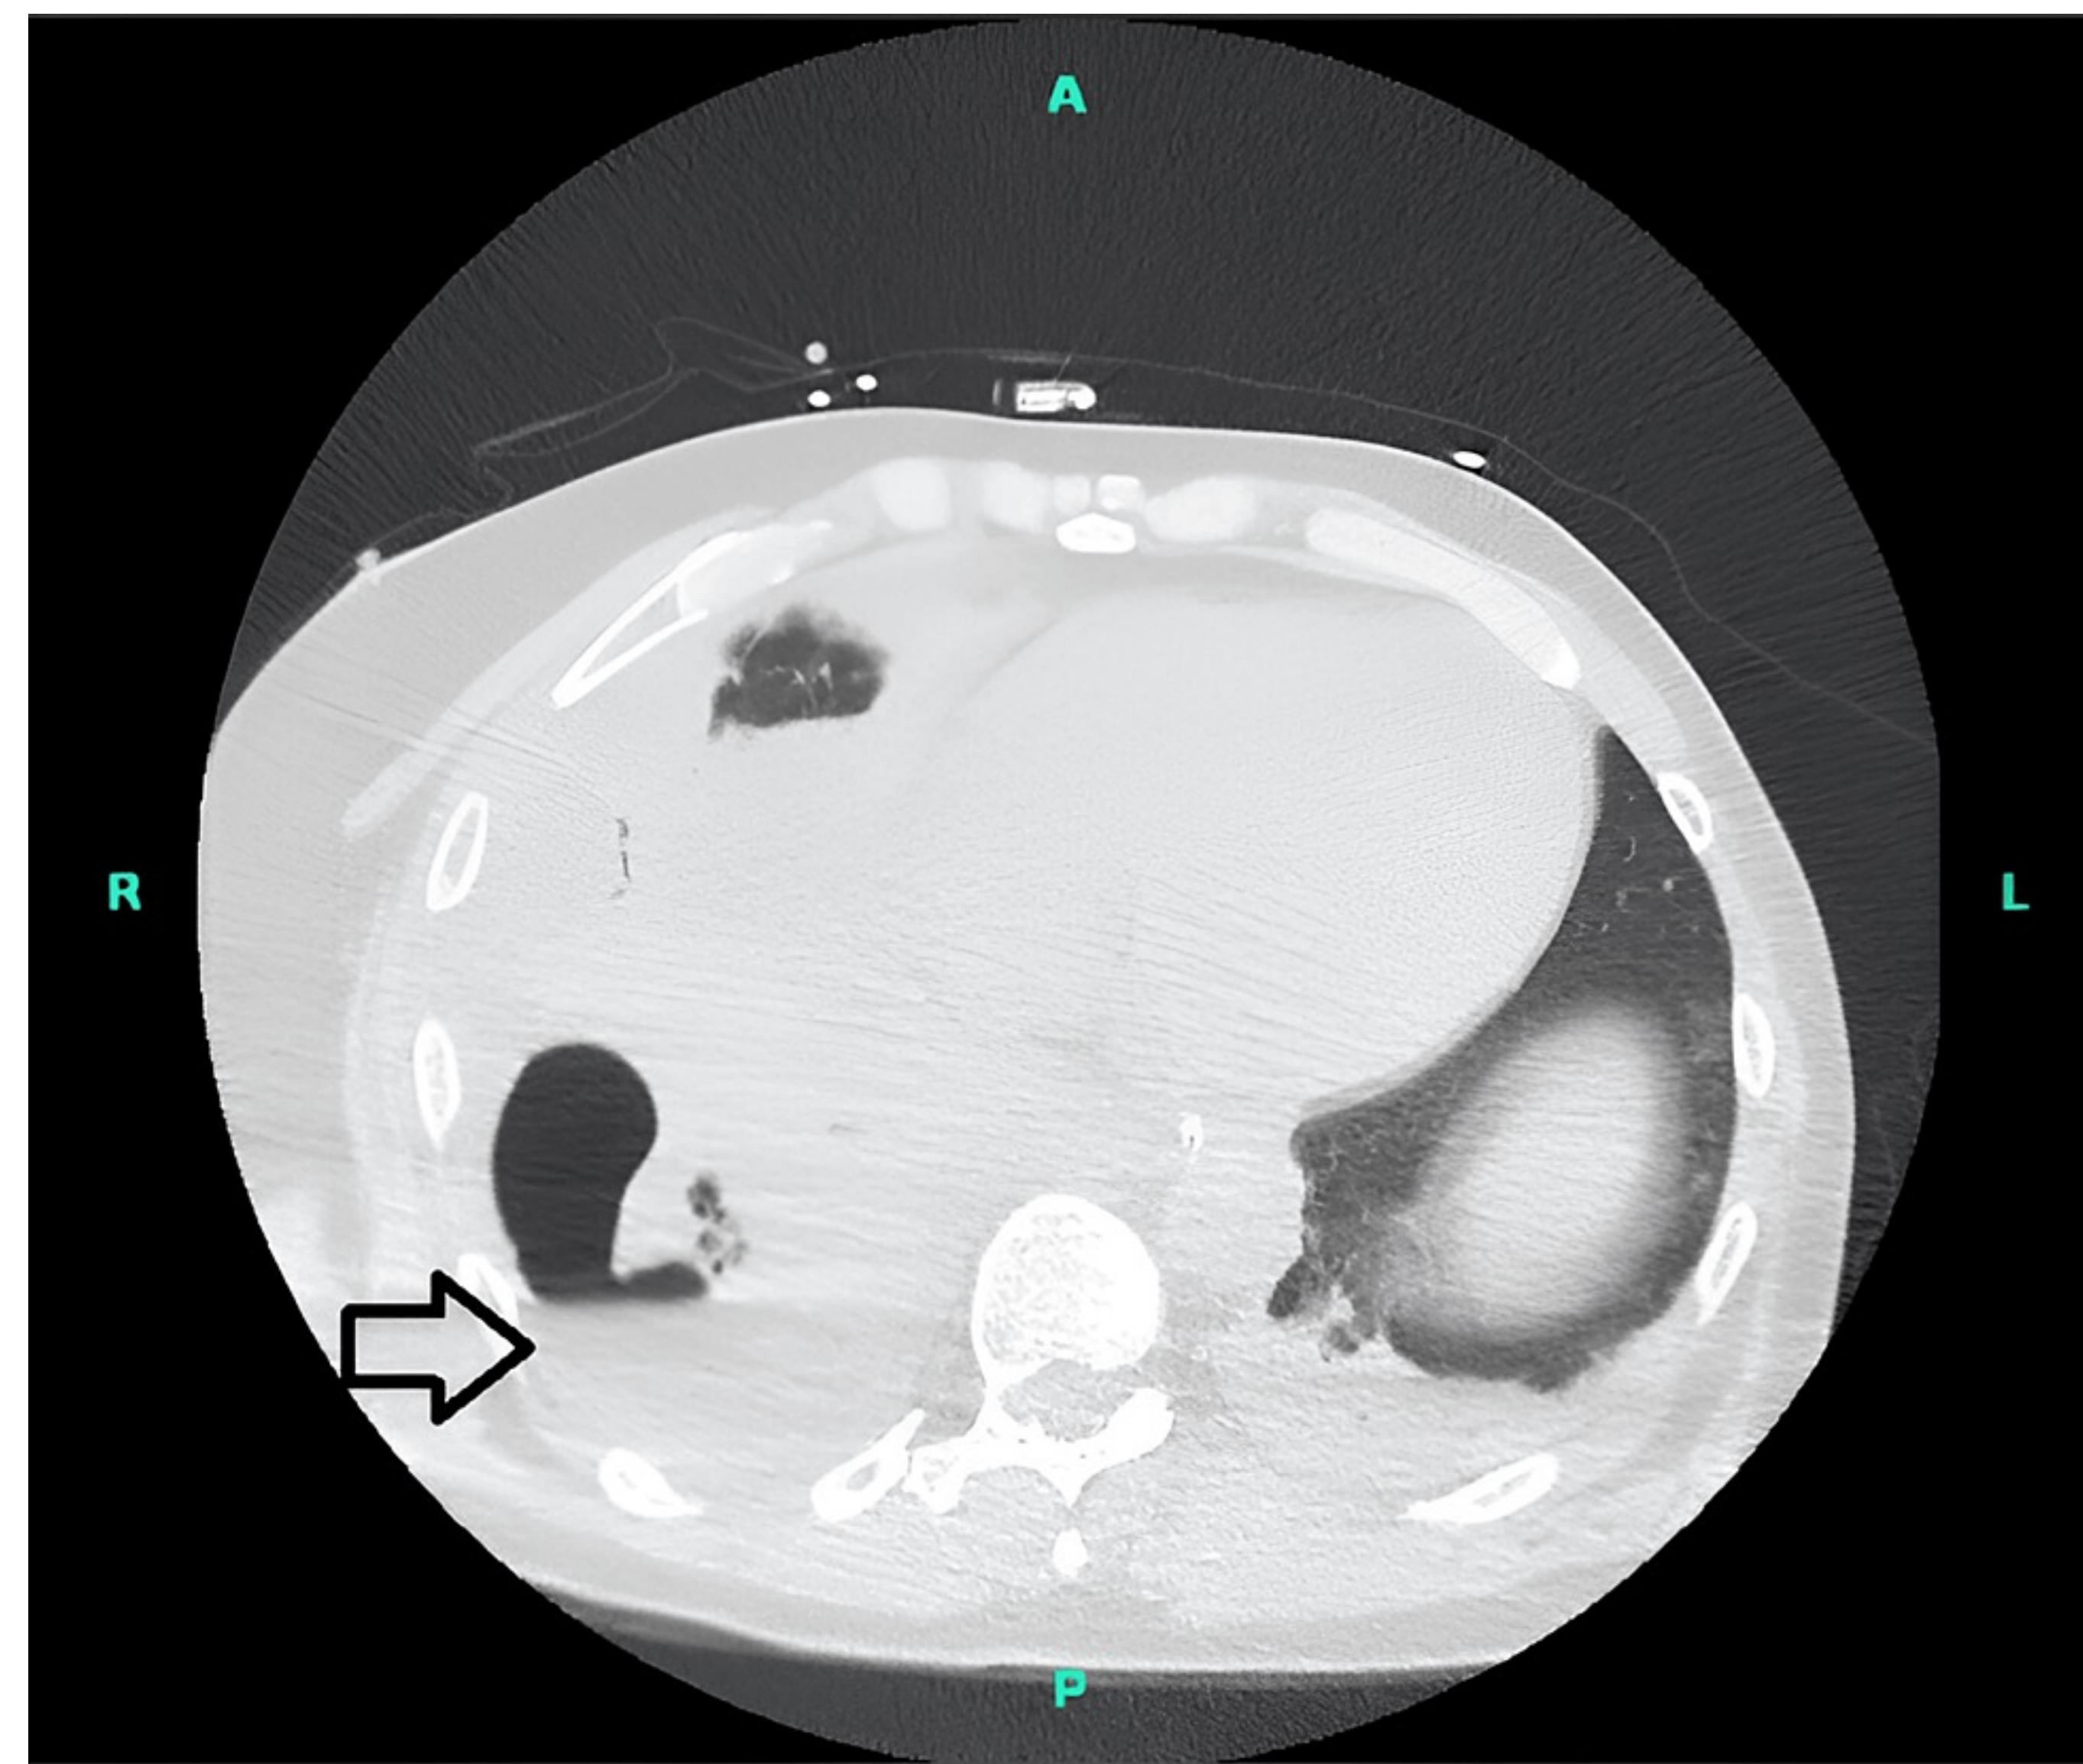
CT chest on day 4 showed fluid collection in the right pleural space (arrow) and bilateral lung consolidation.<sup>2</sup>
